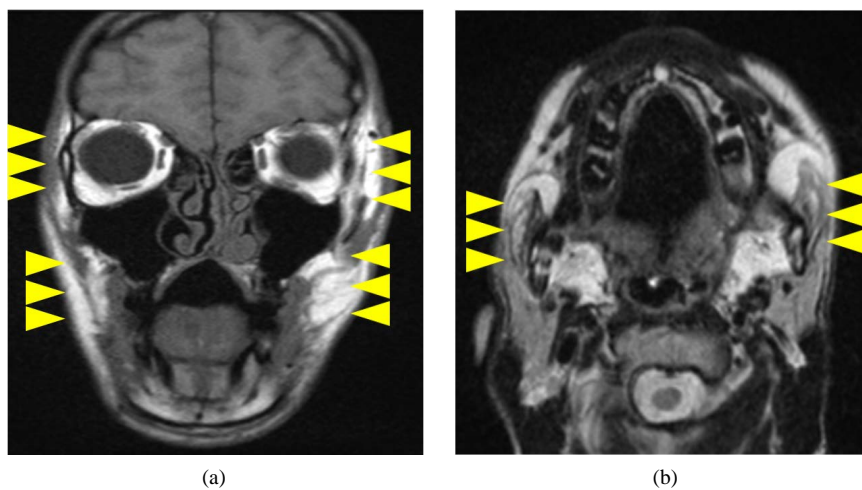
Postoperative MRI shows atrophy and poor development of bilateral masticatory muscles.
